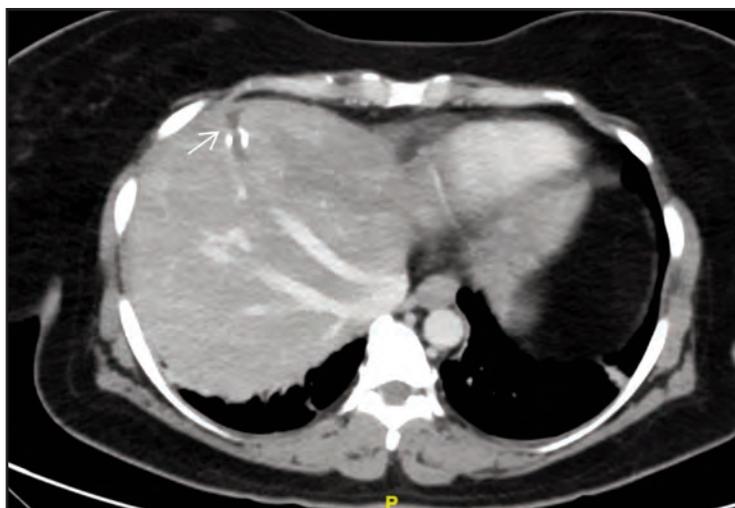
Complete disconnection of the shunt (arrow) based on repeat CT assessment 2 months post-surgical ligation
